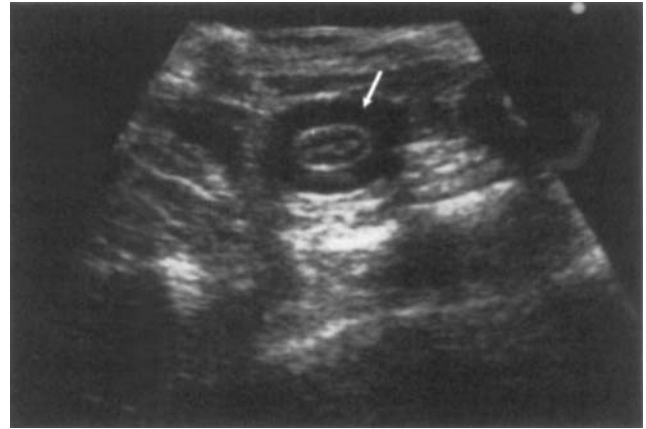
Transverse ultrasound image of the small intestine. Note the increased thickening of the muscular layer (arrow) due to smooth muscle hypertrophy.
